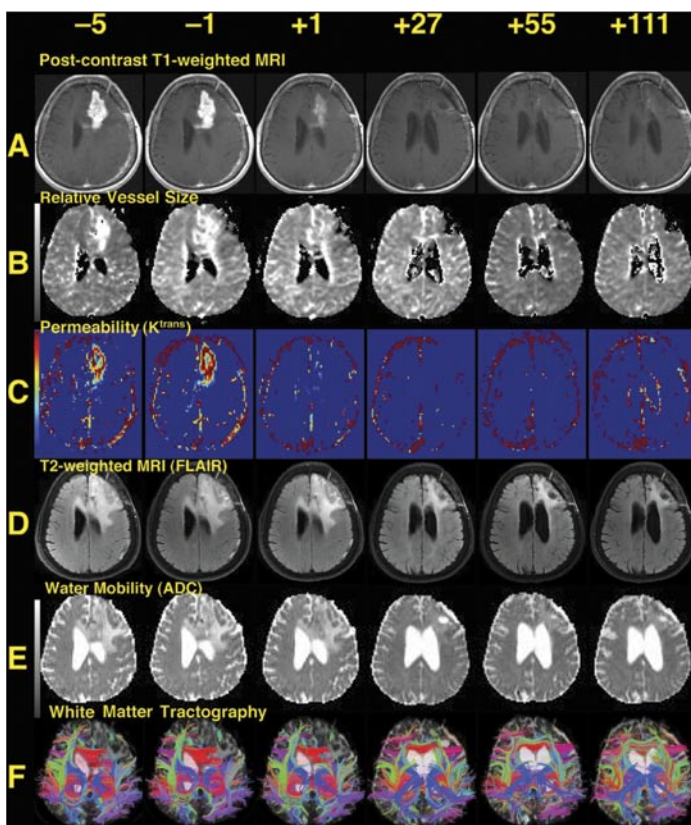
Representative Images From the Best-Responding Patient Receiving Antiangiogenic Therapy. (A) T1-weighted anatomic images after intravenous administration of a contrast agent (gadolinium-DTPA), demonstrating a region of bright signal corresponding to the recurrent brain tumor in the left frontal lobe shrinking over time. Note also the decreased mass effect on the left lateral ventricle. (B) Map of relative microvessel size, also showing decrease over time. (C) Maps of K^{trans} , a measure of blood-brain barrier permeability. Note the substantial change after the first dose. (D) T2-weighted images acquired with a fluid-attenuated inversion recovery sequence (FLAIR), where edema is seen surrounding the tumor enhancement evident in (A), also decreasing over time. (E) Images of apparent diffusion coefficient (ADC) demonstrating water mobility, which identifies areas of vasogenic edema as high (bright) signal surrounding the region of enhancing tumor; these also reduce over time. The displacement of the ventricle is also reduced over time. (F) Tractography. These images demonstrate directional water mobility suggesting the presence of white matter tracts. As the vasogenic edema decreases and the mass effect subsides, these white matter tracts become more evident. All images are displayed per standard radiographic convention.
